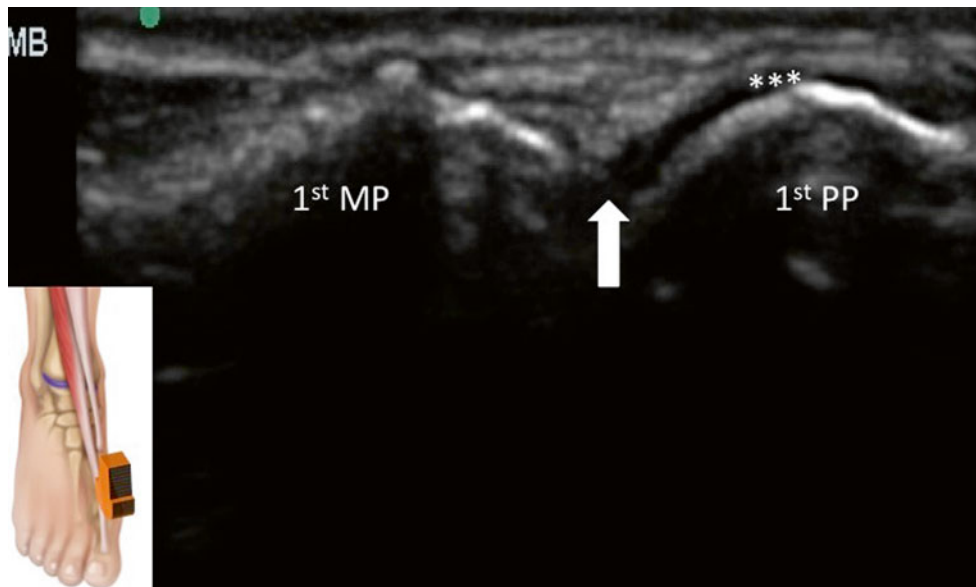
Sonography of the long axis view of the first metatarsophalangeal joint (MTPJ). The ultrasound probe position was indicated in the insert in the left lower corner. The MTPJ was indicated by the bold
